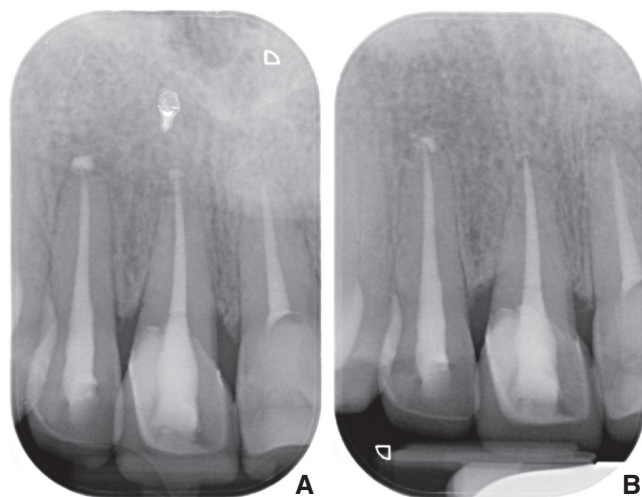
Periapical radiograph. A, After adhesive cementation restorations. B, After 6 years of follow-up.
